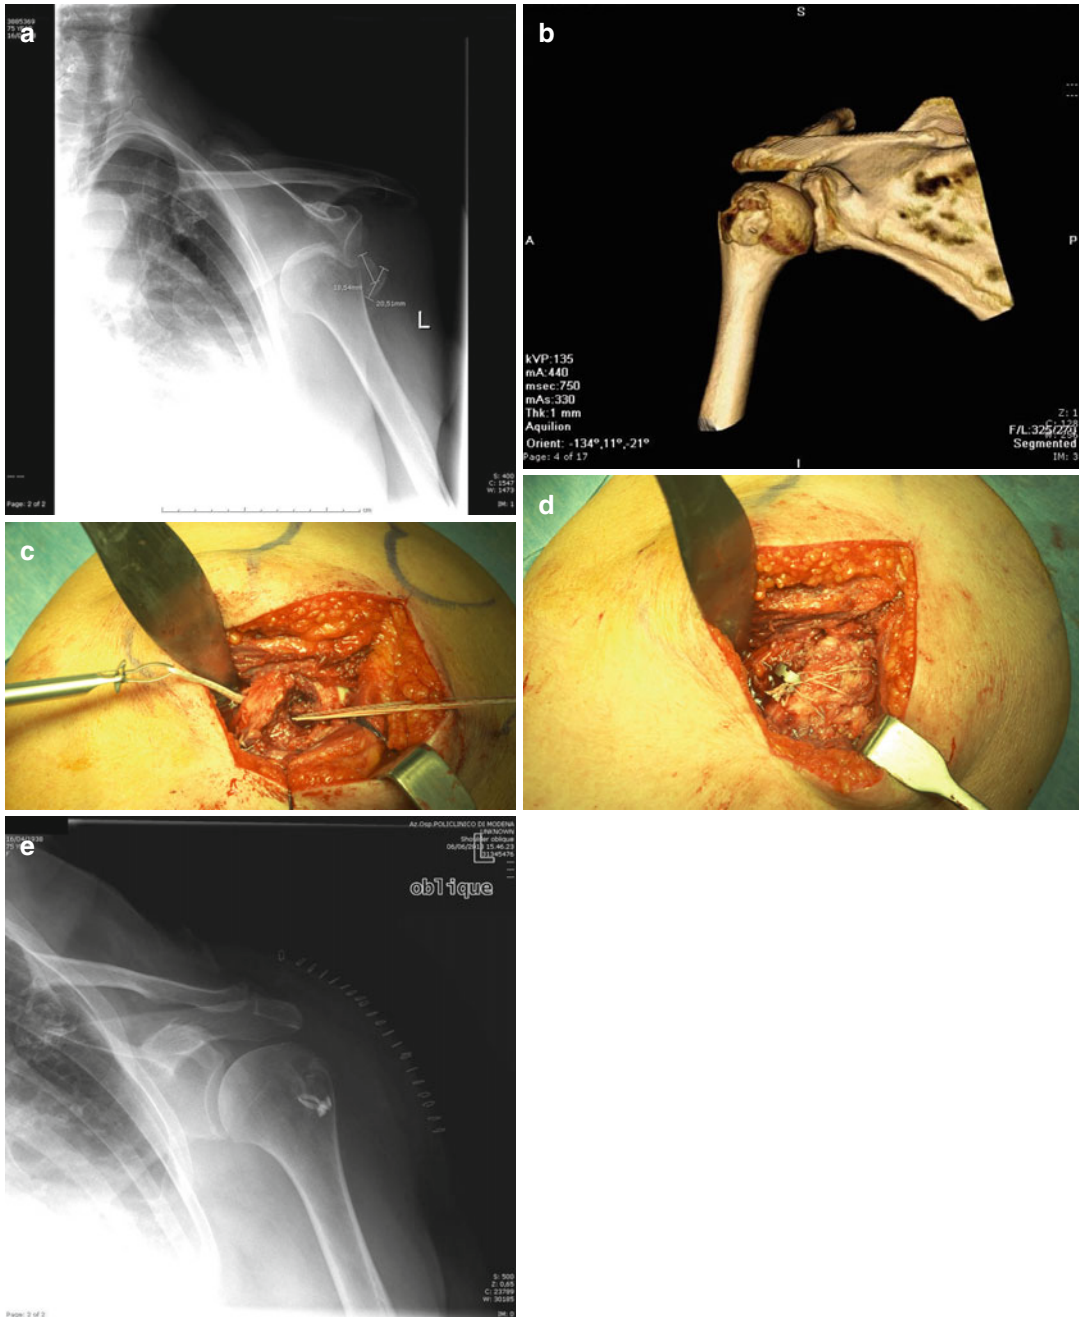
(a) Several fragments of greater tuberosity fracture-dislocation: X-ray. (b) 3D-CT fracture view. (c) Open fixation with transosseous system, the SharcoFT®. (d) Final suture configuration. (e) Postoperative X-ray
